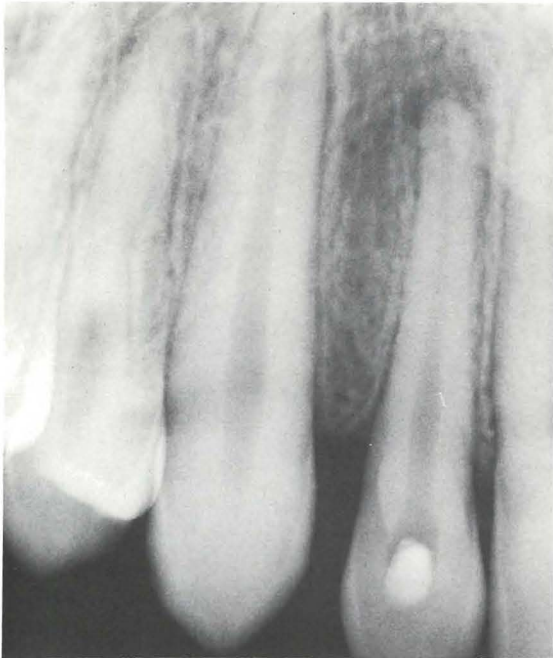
A radiograph taken at the three-month control. The periodontal contour is rough and apical rarefaction is present.
